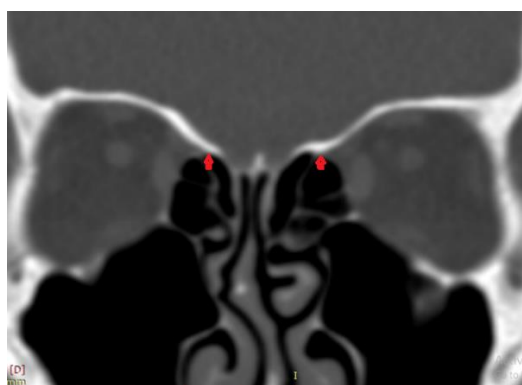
coronal CT scan shows anterior ethmoidal artery (arrow) located within the skull base on both sides
